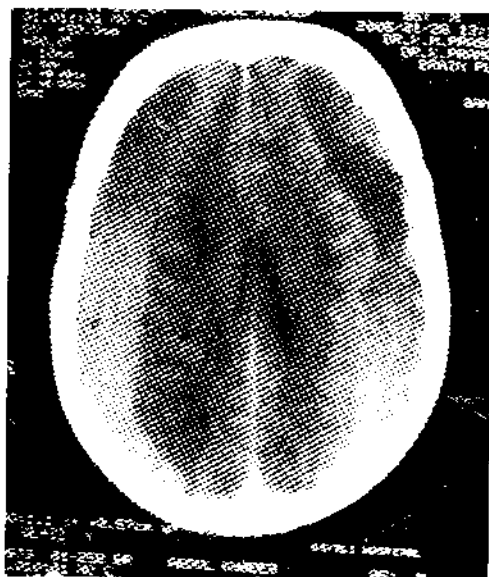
CT scan showing bilateral chronic subdural haematoma
